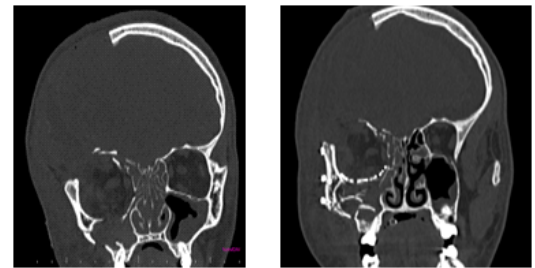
Pre op and Post op CT Coronal view with titanium mesh for orbital floor reconstruction
